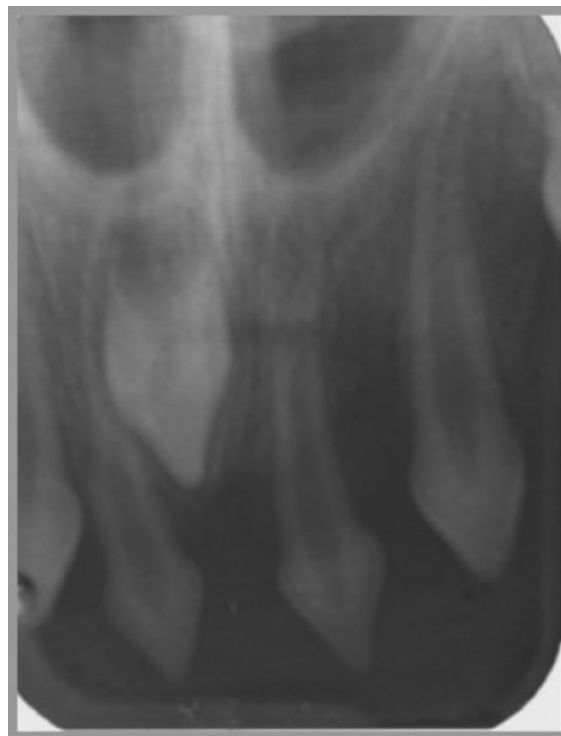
Preoperative intraoral panoramic radiograph.
